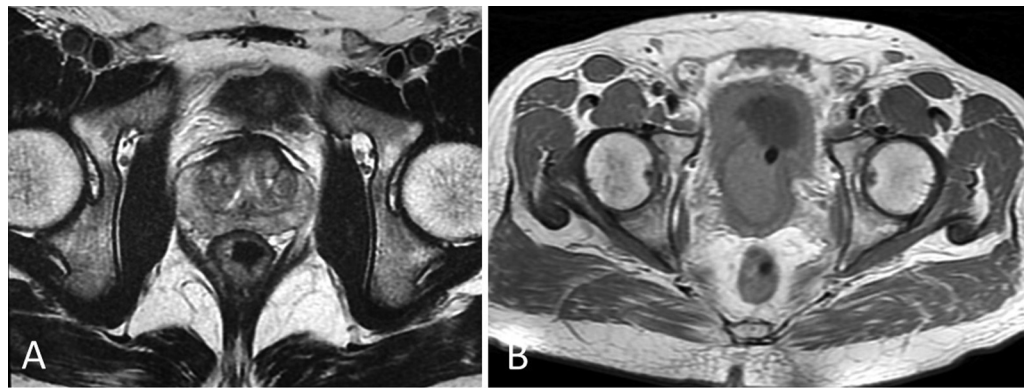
Anatomic coverage for multiparametric magnetic resonance imaging (mp-MRI). Small field of view (FOV) for axial T2-weighted image (T2WI) (A) and large FOV for axial T1WI (B).
